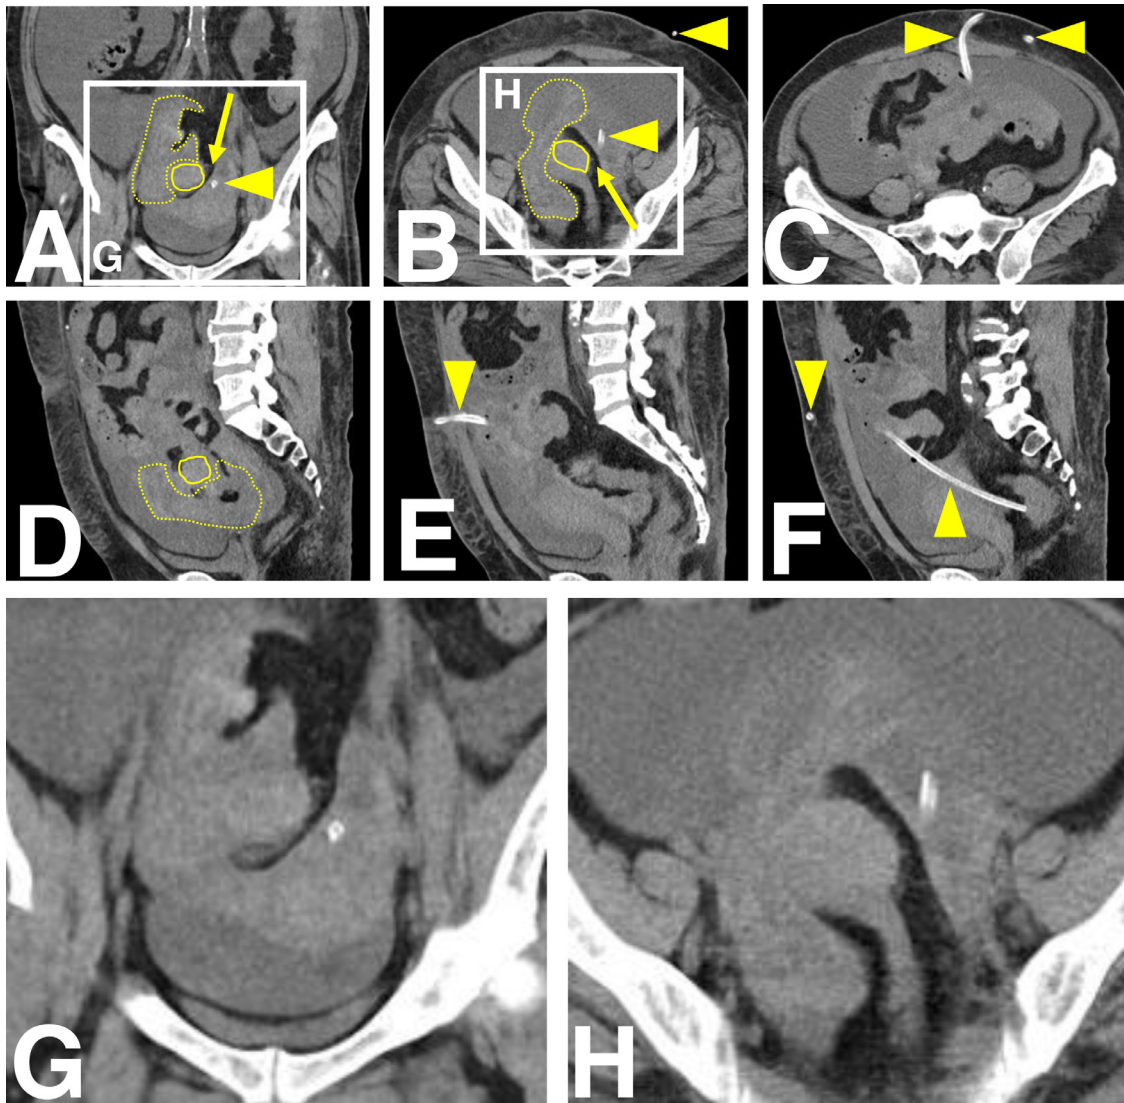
Antemortem non-contrast-enhanced CT images. Circles indicate the mass lesion in the sigmoid colon. Arrowheads indicate the dialysis catheter. Arrows indicate adipose tissue interposed between the mass lesion and dialysis catheter. Dashed circles indicate soft blood clots and fibrin. (A) Coronal-view reconstruction of abdominal computed tomography (CT). (B) Axial-view image from pelvic CT. (C) Axial image taken 4.5 cm cranial from Image B. (D) Sagittal-view reconstruction of abdominal CT. (E) Sagittal-view image taken 2.1 cm to the left of Image D. (F) Sagittal-view image taken 1.2 cm to the left of Image E. (G) Enlargement of Image A. (H) Enlargement of Image B.
